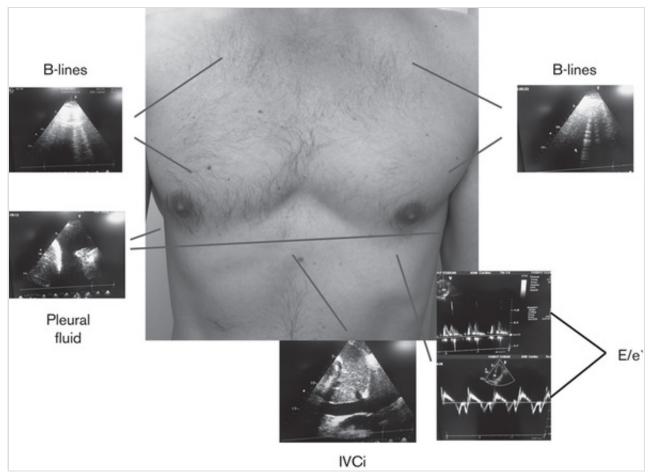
An overview of the cardiothoracic ultrasound protocol protocol and the inferior vena cava index (IVCi) in addition.
